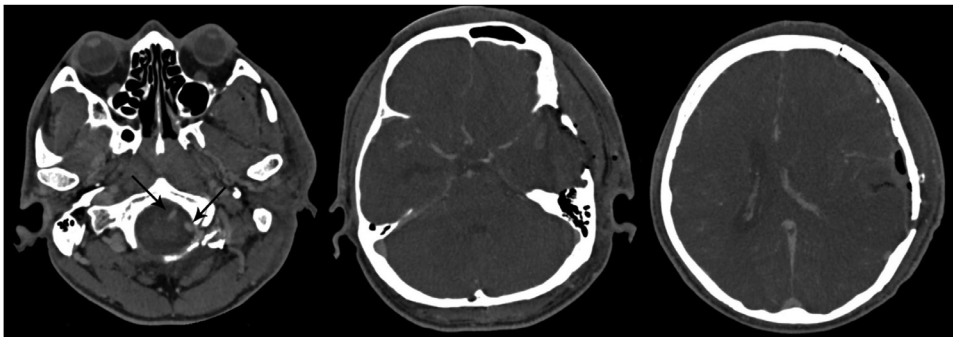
“Delayed phase” of CTA showed enhancement of all the arteries and veins, including bilateral vertebral arteries (arrows).
